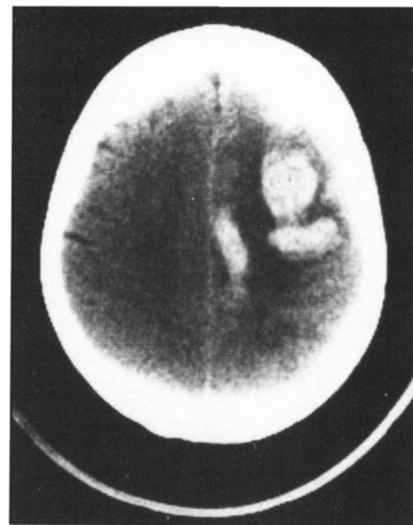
Cranial CT scan after the third hemorrhage; this time the hemorrhage involves the area of the previous cerebral infarction.
